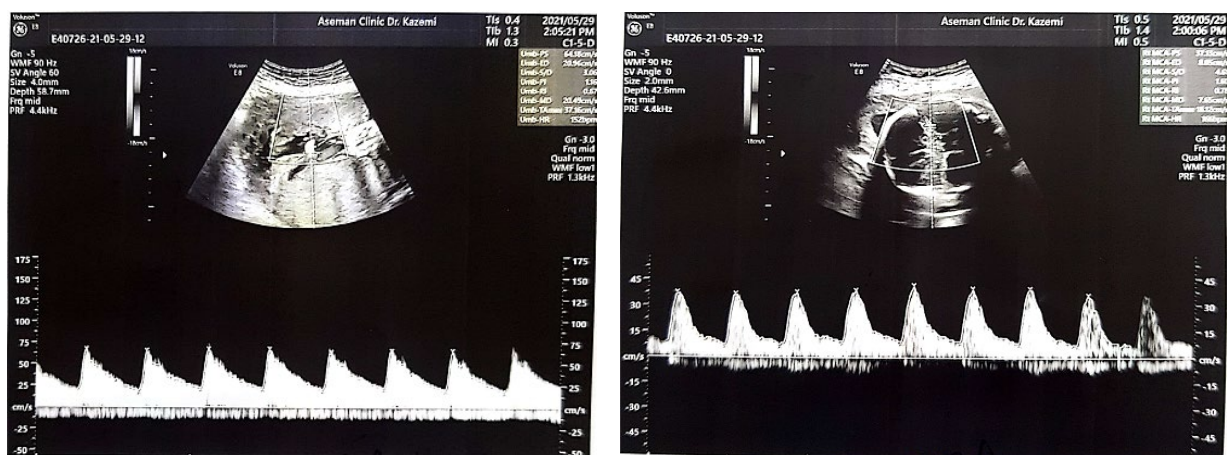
Doppler ultrasound study showing reversed MCA/UA PI
